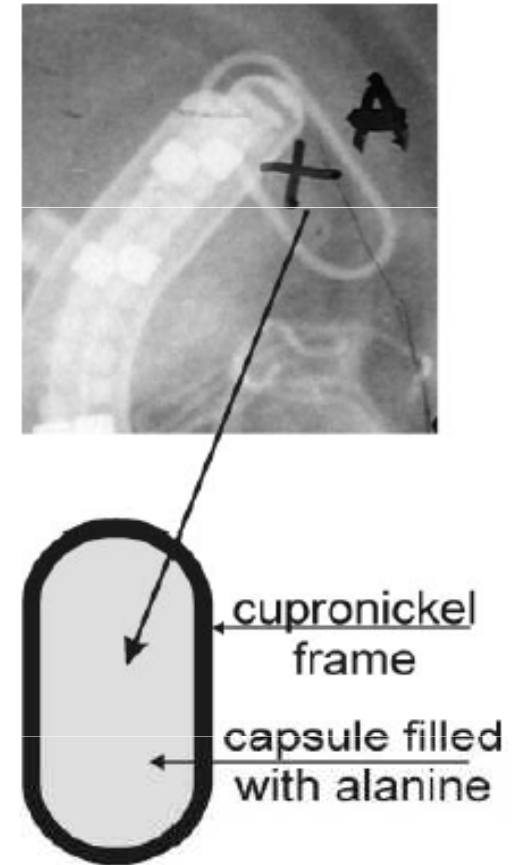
Visualisation of a detector on radiograph used for treatment planning. The cross marks the central point of the detector in which the dose was calculated by RTP.
